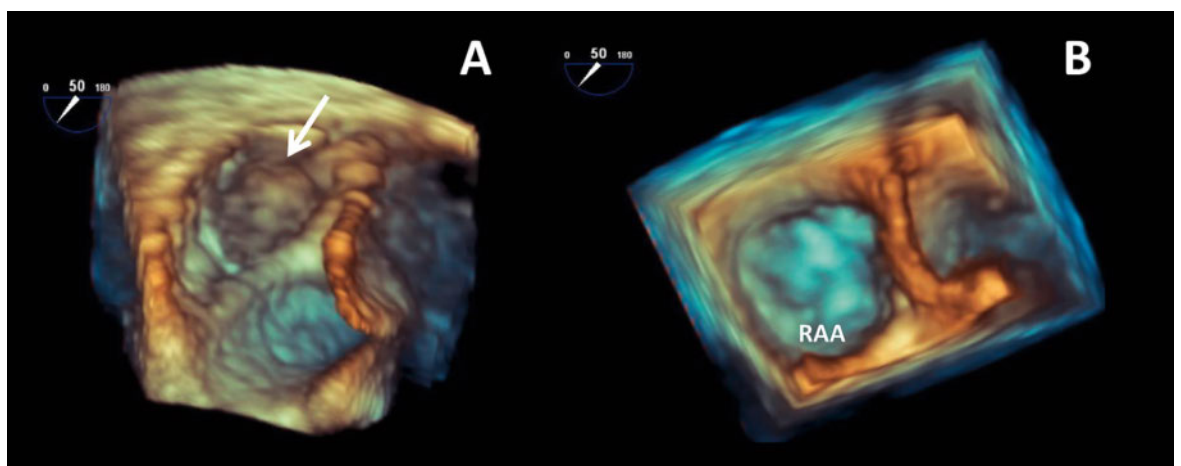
3-Dimensional transoesophageal echocardiography; (A) white arrow points at thrombus in right atrial appendage; (B) 3 months later after anticoagulation.
